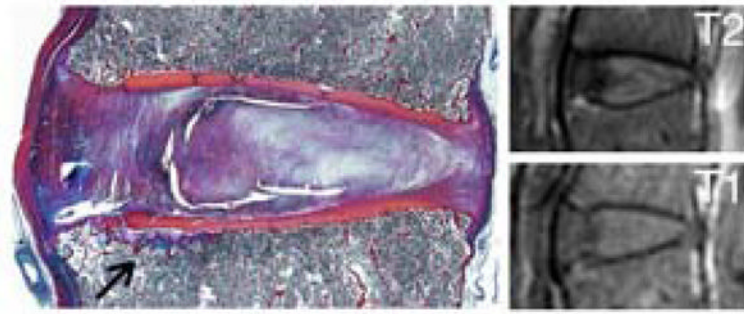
Endplate cartilage avulsion with fibrovascular marrow (left) and corresponding MR images (right). Donor information: 63-year-old woman; L3–L4 disc.
